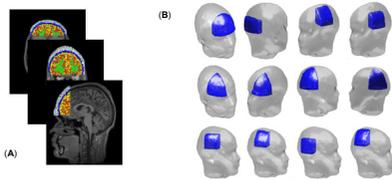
MRI-based segmented FEM brain mesh library.
